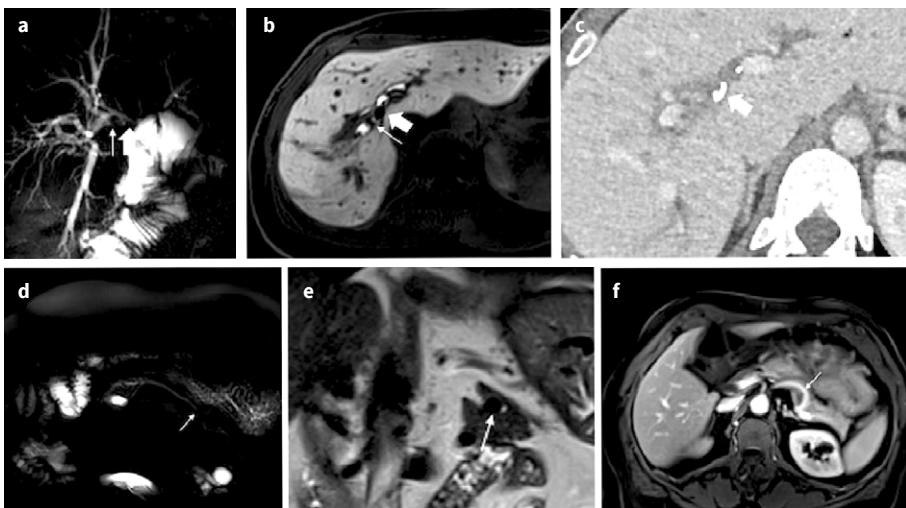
Interpreting intraductal findings. a–c | Intraductal filling defects. a | MRCP shows two intraductal filling defects (arrows). b | T1-weighted image of the hepatobilary phase shows that the structures have different signals as one is a stone (thin arrow) and the other is a metallic clip (thick arrow) causing a blooming artefact. c | CT confirms the presence of a metallic clip (thick arrow). d–f | Pulsation artefact. MRCP shows a pancreatic tail duct stricture (arrow)(d) that is actually a pseudostricture caused by the adjacent splenic artery, as seen in the T2-weighted image (arrow) (e) and the T1-weighted post-contrast image (arrow) (f).
